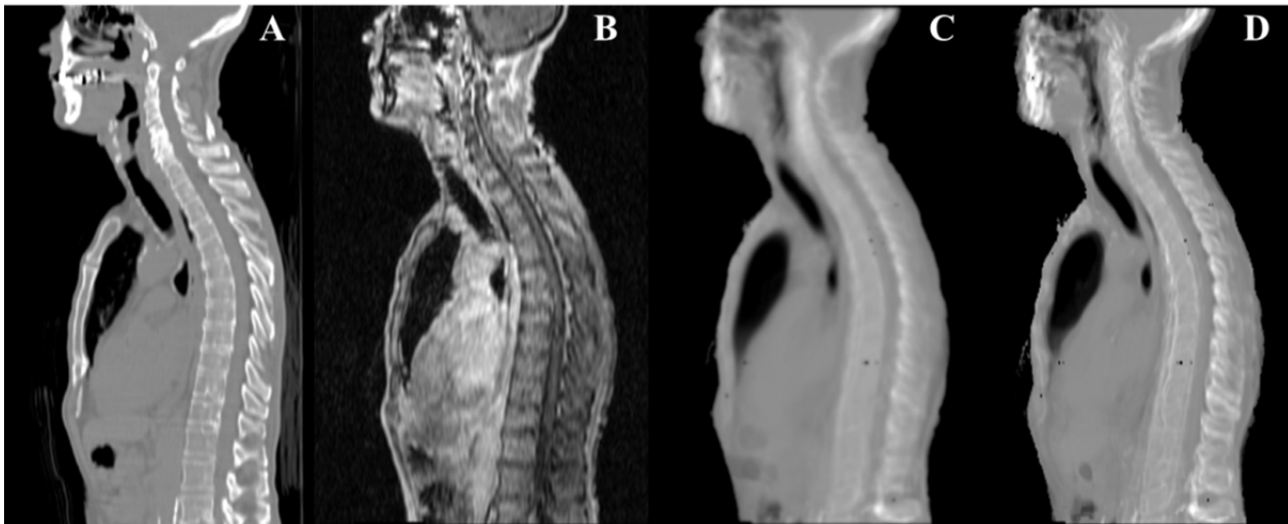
A) Target patient CT image, B) corresponding in-phase MR image, and attenuation maps generated using C) Hofmann's technique and D) our proposed SAP approach.
